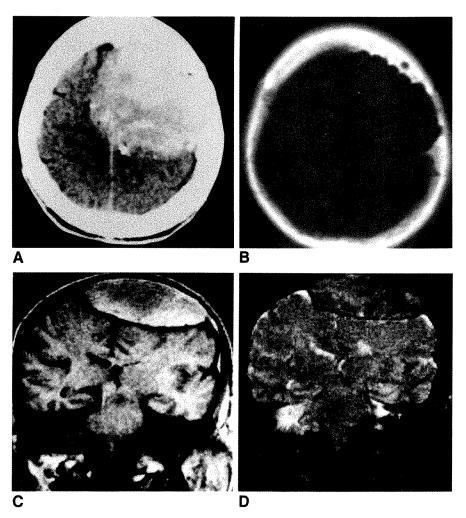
Case 3: Plasmacytoma of skull vault. A, Noncontrast axial head CT scan near vertex shows a hyperdense mass, with focal areas of higher density suggesting calcification. Lesion crosses midline.
